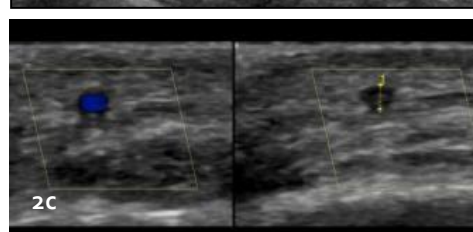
Transverse view of halo in superficial TA. 2b: Longitudinal view of halo in superficial TA [Image 2a and 2b show B-flow Doppler assessment]. 2c: Demonstrates non-compressible halo in superficial TA. TA still visible despite probe compression.
